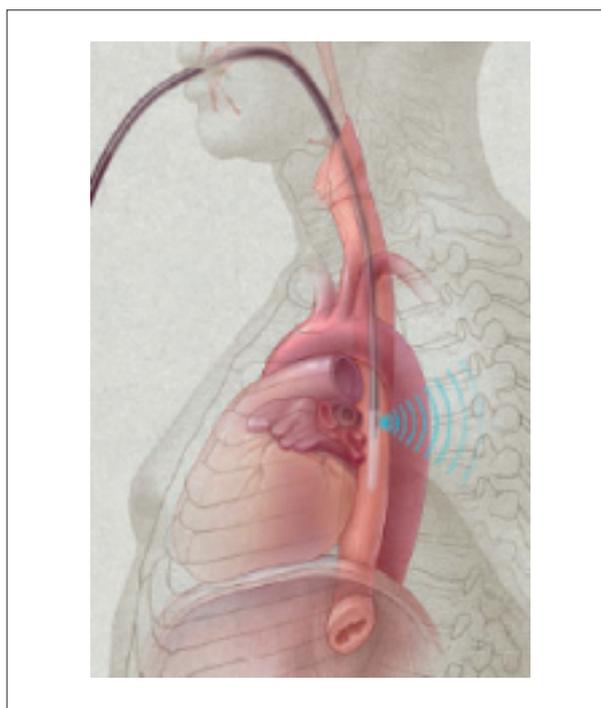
Placement of the transesophageal Doppler probe next to the descending aorta.
